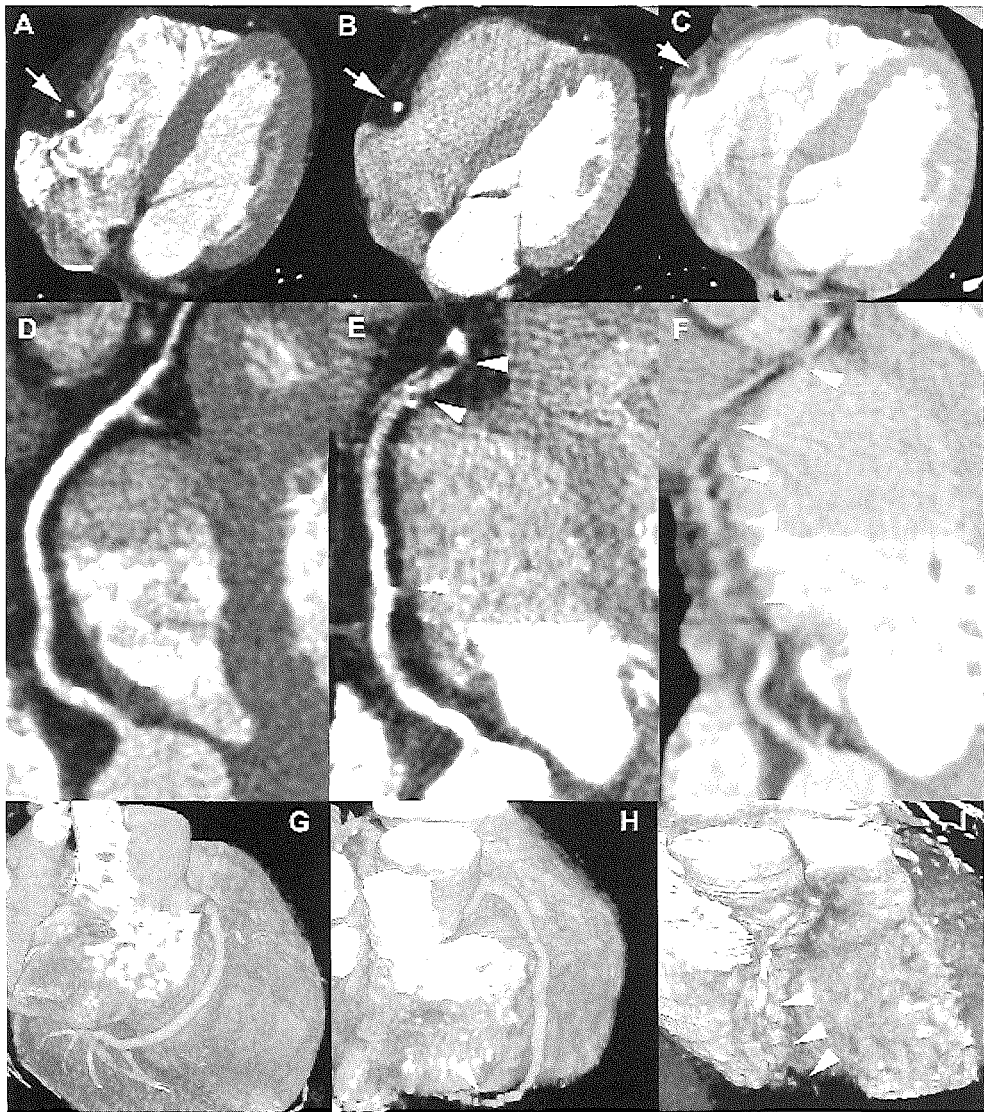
Multislice computed tomography (MSCT) angiograms at different heart rates. The axial source images (A,B,C), curved multiplanar reconstructions (D,E,F), and volume rendered reconstructions (G,H,I) of a normal right coronary artery (RCA, arrows) in patients with an average heart rate of 49 beats/min (A,D,G), 64 beats/min (B,E,H), and 81 beats/min (C,F,I), respectively, are shown. Motion artefacts (arrowheads) hinder assessment of the distal RCA in the second case and nearly the entire RCA in the third. RV, right ventricle.
